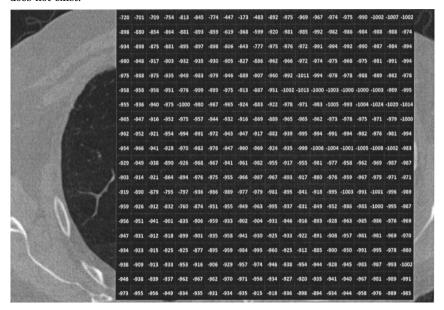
Pixel numbers superimposed on a chest CT scan.
